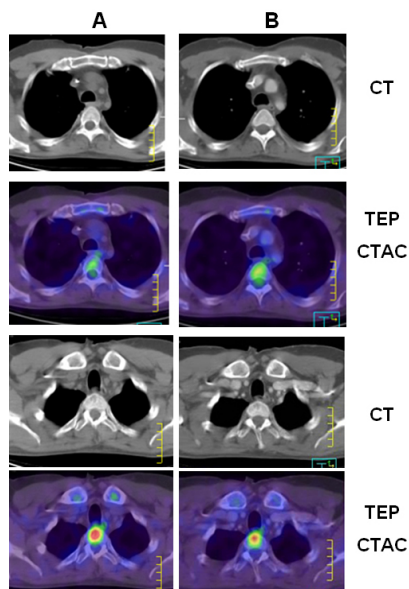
No difference for malignancy diagnosis on CTAC images corrected by ICT and dCT — upper: non metastatic vertebra — lower: metastatic vertebra A: non injected CT — B: injected CT
